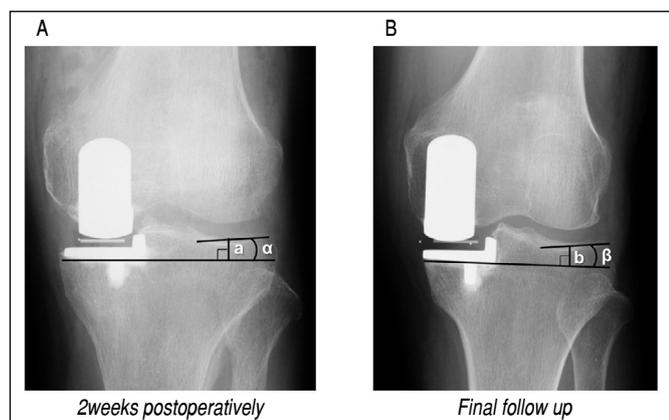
Assessment of tibial component subsidence. The subsidence of the tibial component was evaluated according to changes in radiographic parameters from 2 weeks postoperatively (A); to final follow-up (B). Subsidence distance (mm) = $b - a$. Subsidence angle ($^{\circ}$) = $\beta - \alpha$.
